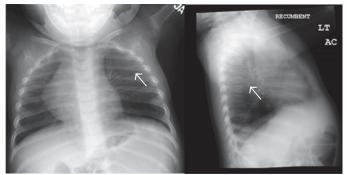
Chest X-ray AP and lateral -left lower lobe CPAM
